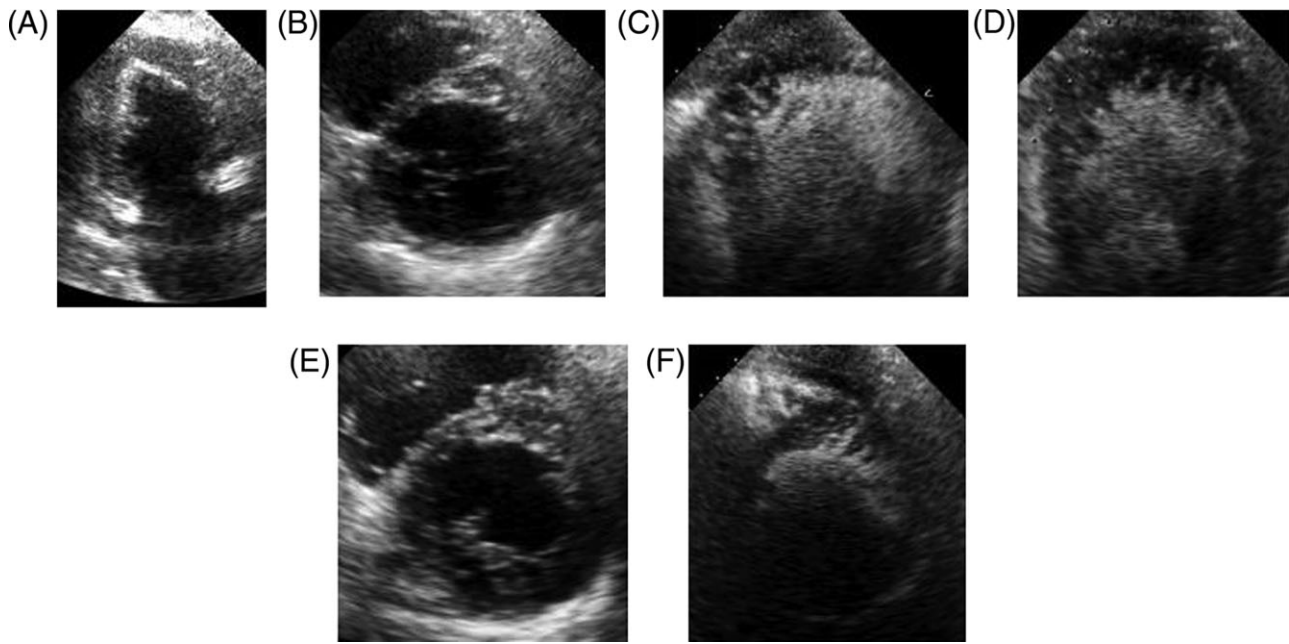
Images from Family 5. (A) Apical two-chamber view patient II:2 shows apical hypertrophy without apparent trabeculation. (B) Short axis midventricular view of the same patient showing anterolateral hypertrophy. (C) Contrast echocardiography of patient II:1 shows deep apical invagination. (D) Contrast echocardiography of patient II:1 showing a detail of the apical trabeculation. (E) Short axis midventricular view of the same patient (II:1) similar to (B) (they are sisters). (F) Contrast echo in the same patient (II:1) demonstrates prominent trabeculations and deep invaginations with a thin epicardial layer.
